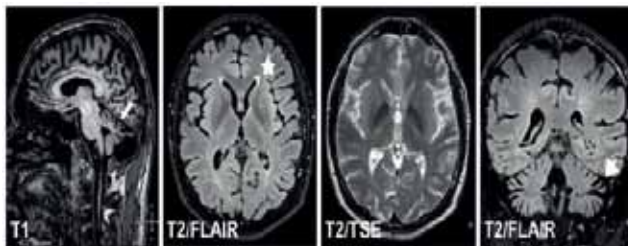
Brain MRI of patients HSP84.II.3 with vermian and hemispheric cerebellar atrophy (white arrowheads) and 'ear of the lynx' sign (T2 hyperintensity of the anterior fornix of the corpus Callosum (asterisk))
